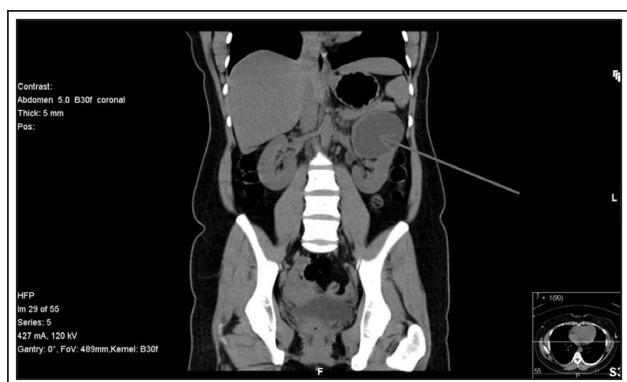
Unenhanced CT shows a 6.8 cm x 6.4 cm upper pole cyst in the left kidney.
